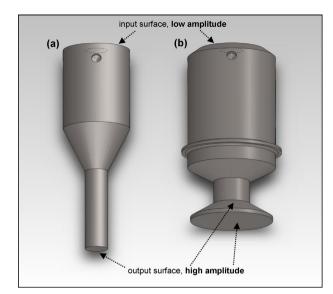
High gain ultrasonic horns: (a) conventional horn (CH); (b) half-wave Barbell Horn (HBH). HBH is able to provide similar amplitude amplification as CH, while providing two high-amplitude radiating zones with a significantly larger cumulative output surface area.
